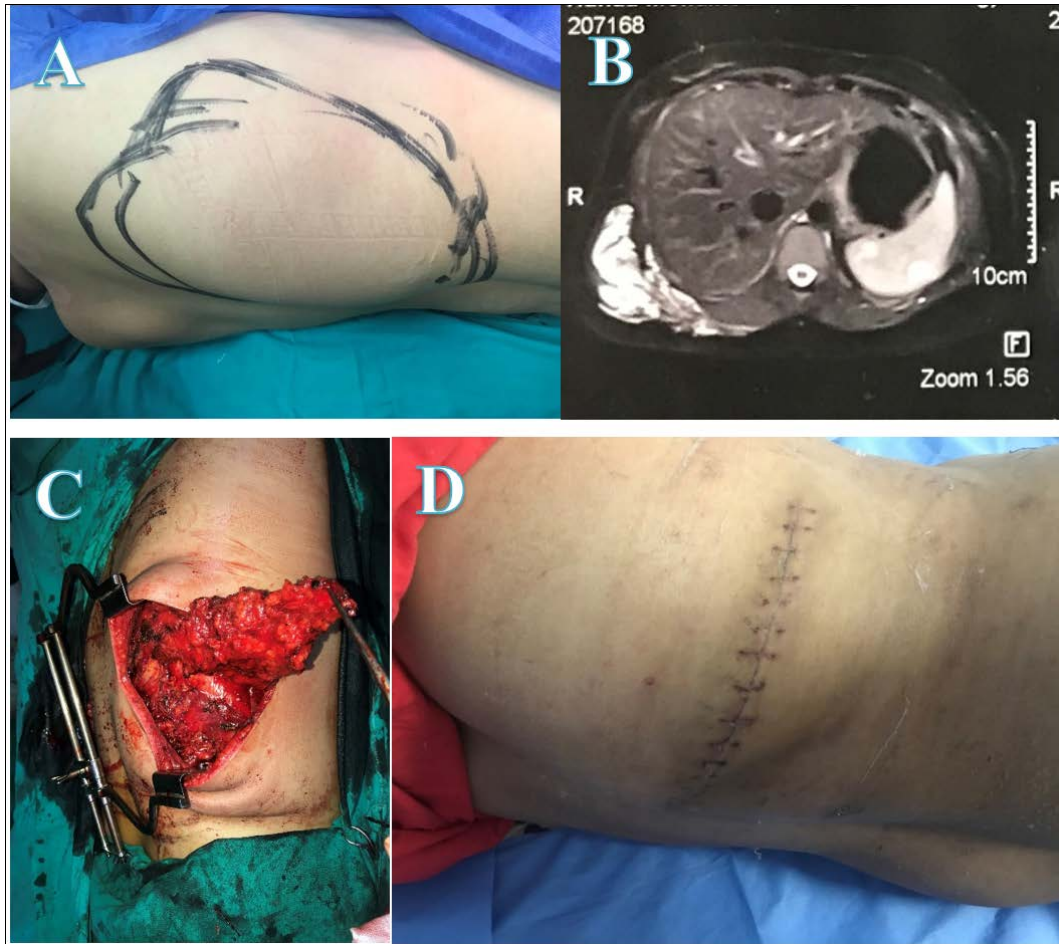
Female patient aged 38 years old presented with a large painful mass in the right side of the chest and back (A). Contrast enhanced MRI angiography showed high signal intensity on T2 and delayed post-contrast enhancement suggestive of venous malformation (B). Significant fatty element was observed in the images denoting poor response to sclerotherapy. Surgical excision was done through a transverse incision with caution to preserve the long thoracic nerve (C). At follow-up, the patient had complete wound healing and was pain free after the excision of the mass (D).
